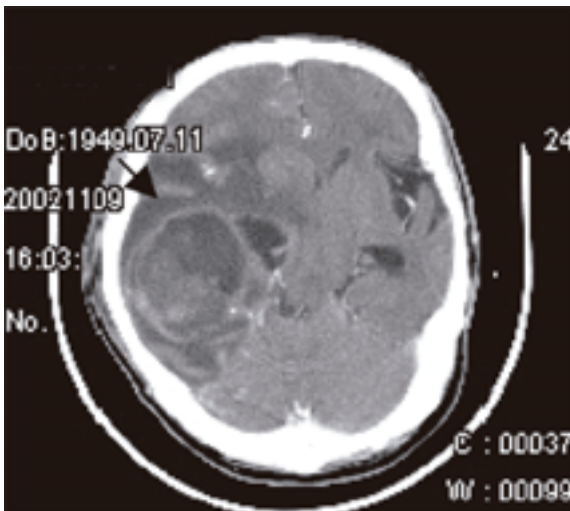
Enhanced axial CT image shows a large multiloculated rim- enhancing right temporal lobe cyst (arrow) with adjacent mass effect.
